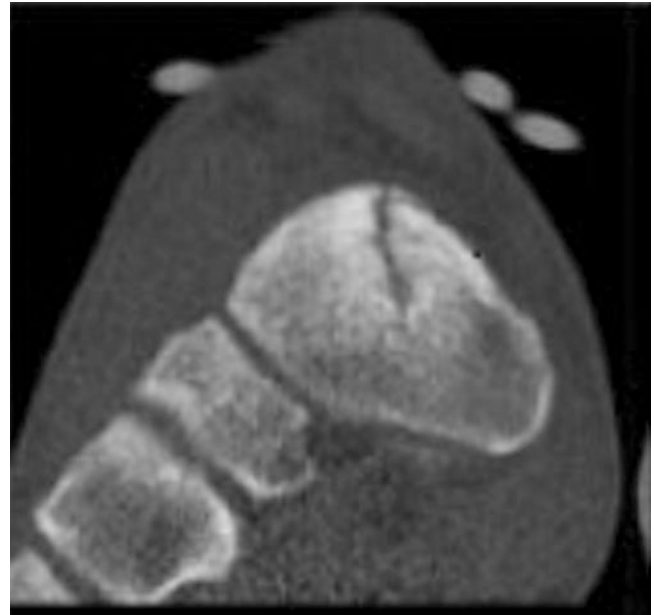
Coronal CT scan demonstrating sagittal dorsal navicular stress fracture
